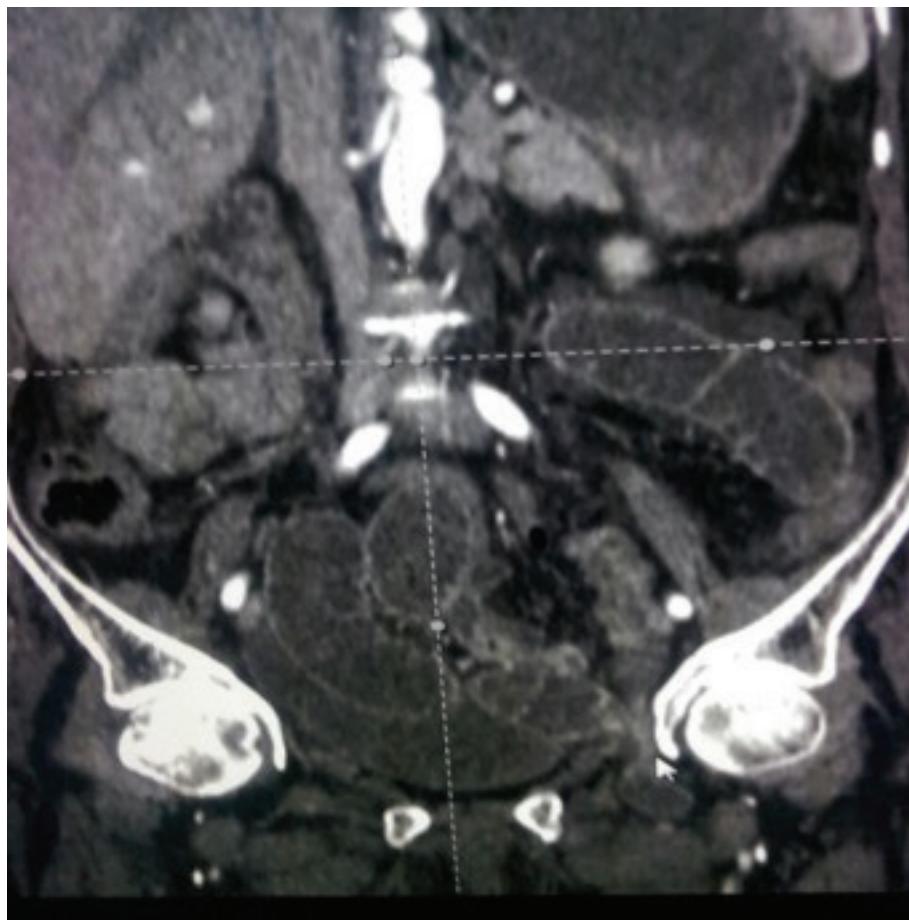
CT scan image of obturatuar hernia.
